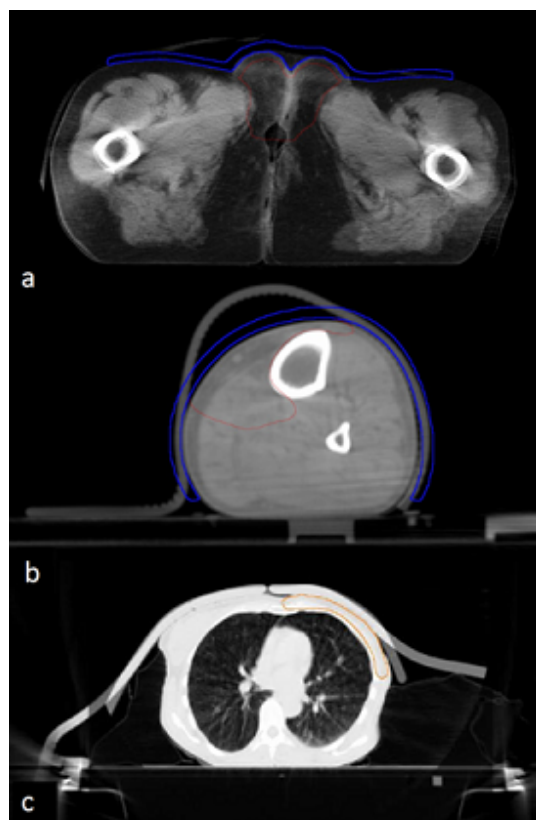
Comparison of bolus position between CT and CBCT images.
